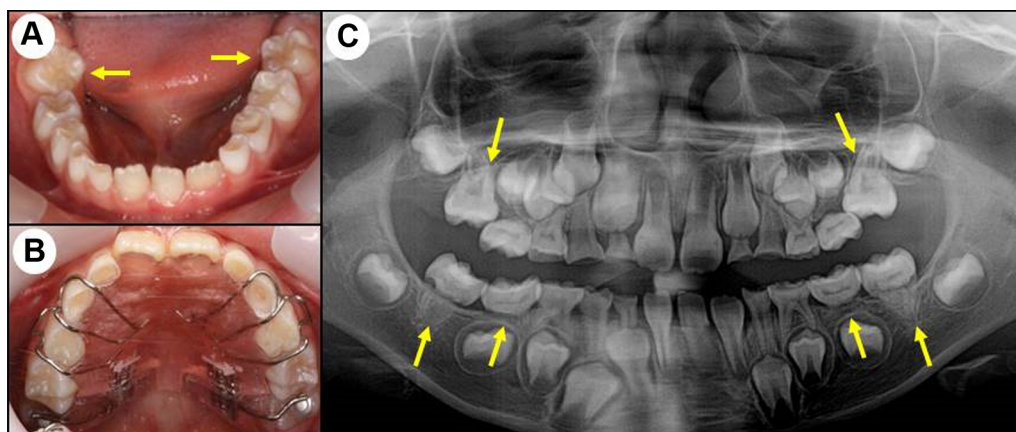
Case 3 (patient 3). Clinical photographs and radiographic film. A, Clinical intraoral photograph (mandible) of a girl (at 7 years and 6 months old) obtained on the first visit. Rotation of the lower bilateral first permanent molars is evident (yellow arrows). B, Clinical intraoral photograph (maxilla) obtained 9 months after the first visit, showing a removable appliance with a distal screw for the relief of impaction of the upper bilateral first permanent molars. C, Panoramic film obtained at the same time as A. The roots of the lower bilateral first permanent molars are thin and divergent, and constriction of the pulp cavities is evident. The roots of the upper and lower bilateral second primary molars are not developed, and the upper bilateral first permanent molars show impaction (yellow arrow).
